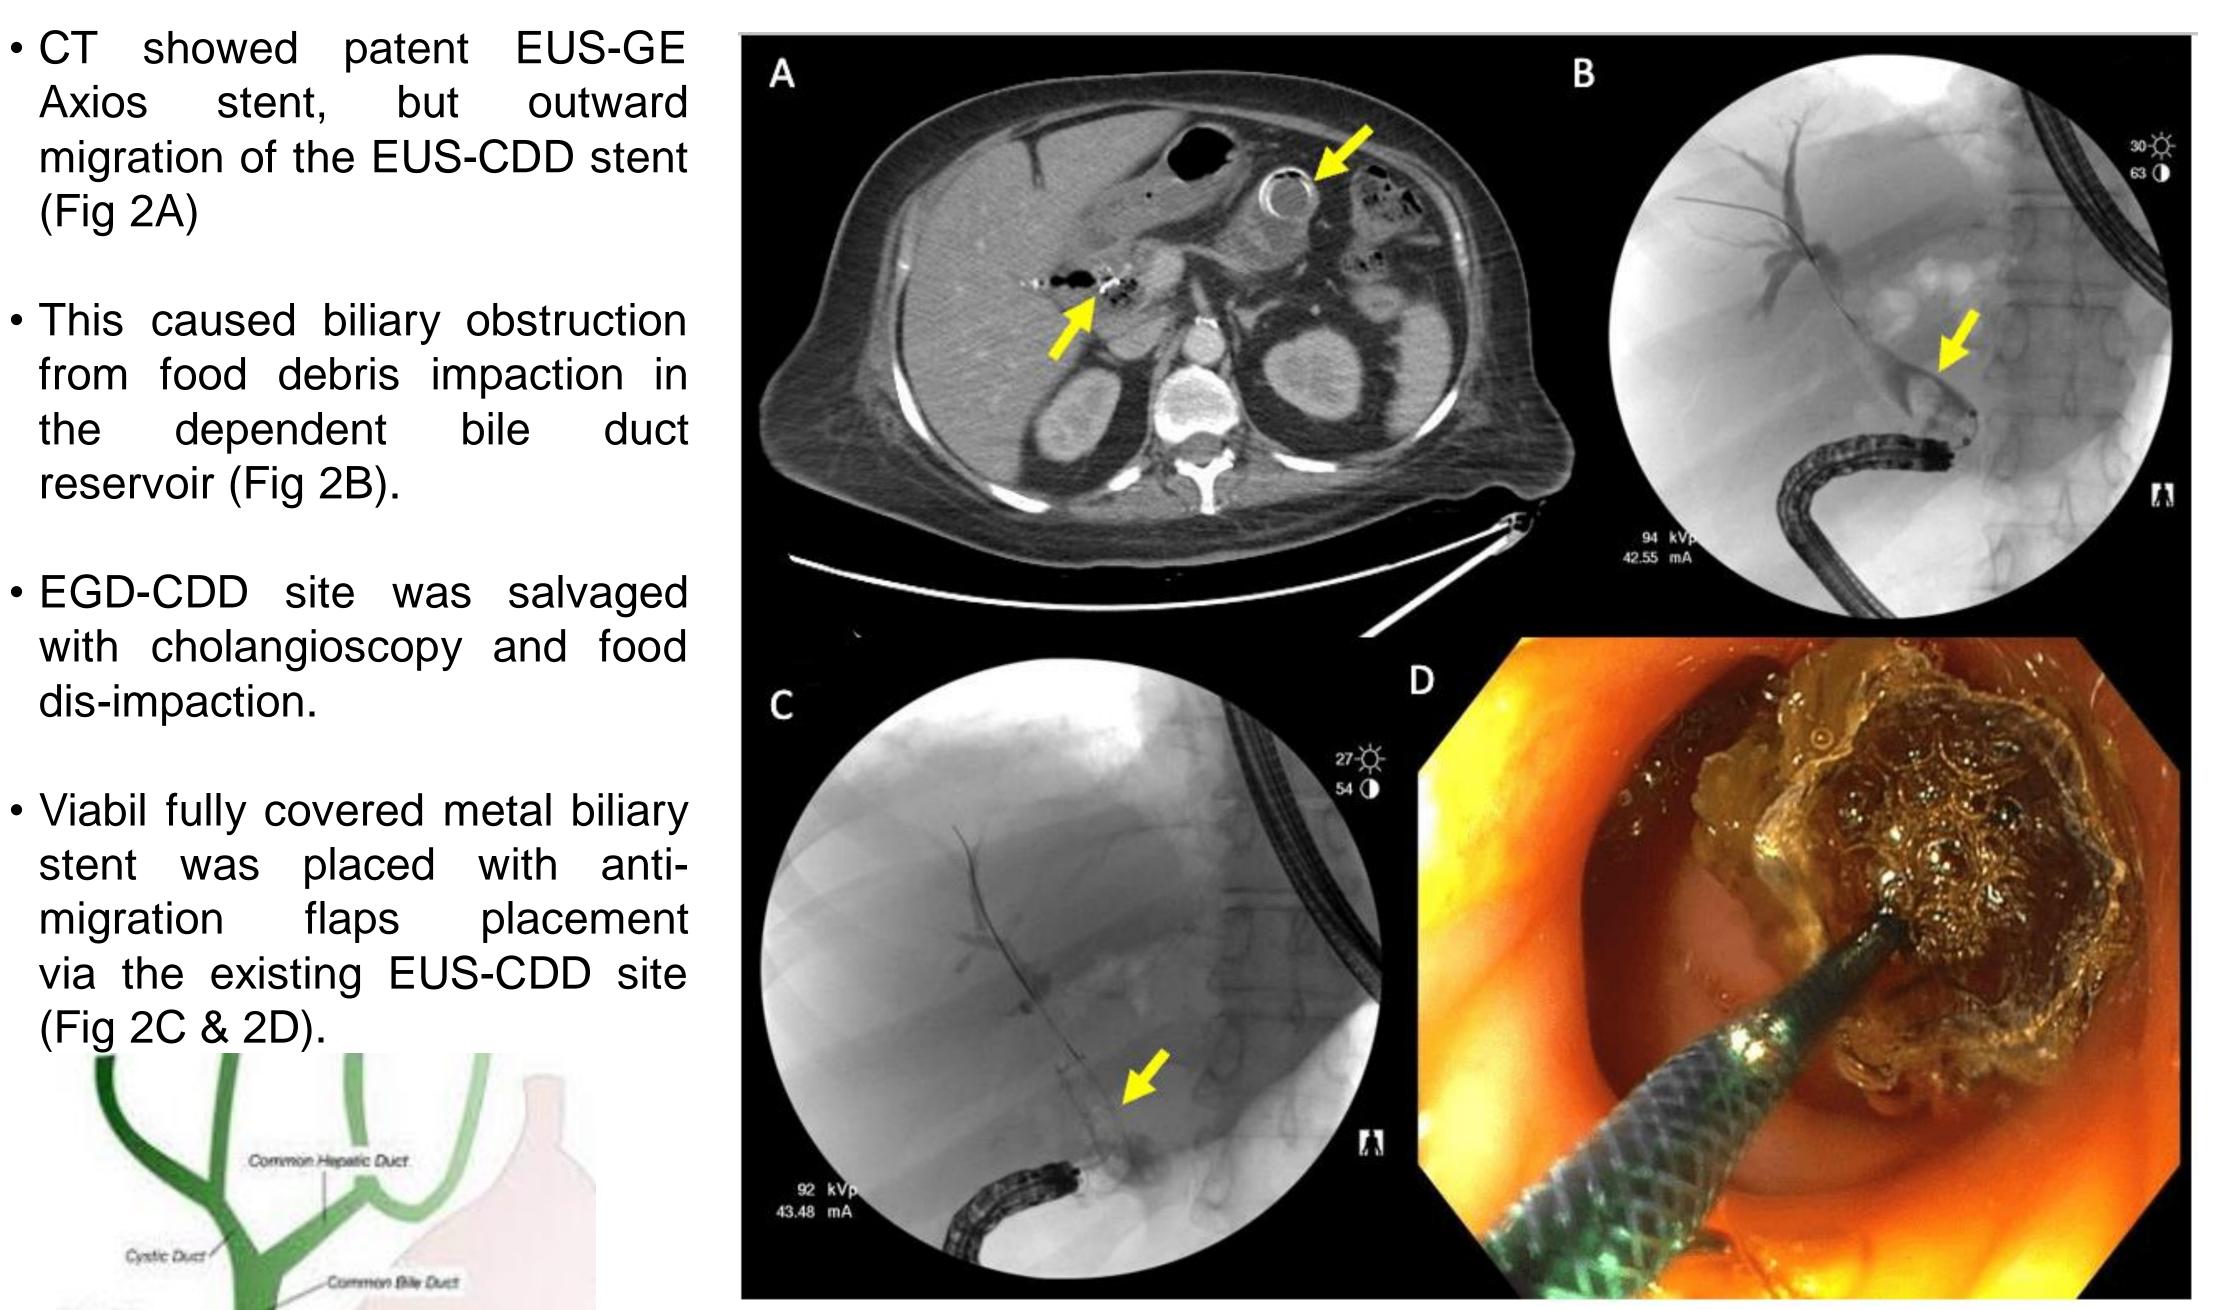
Abdominal computed tomography with left arrow showing displaced CDD stent and right showing patent Axios EUS-GE stent.
